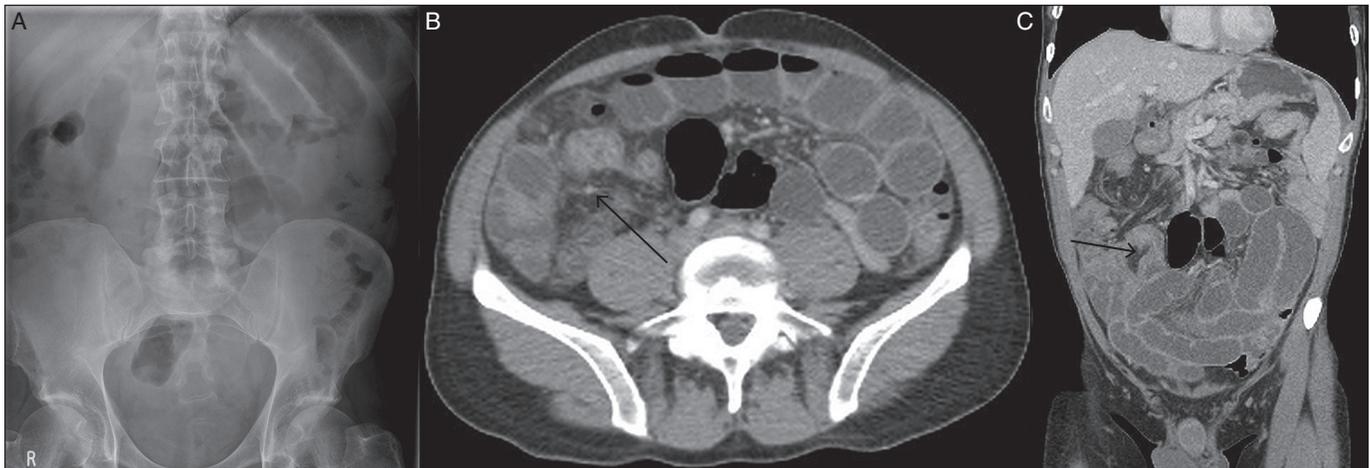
(A) Abdominal x-ray at the time of initial presentation demonstrating small bowel obstruction. (B and C) CT enterogram demonstrating small bowel obstruction with a fibrofatty band (arrow) at the transition point.
